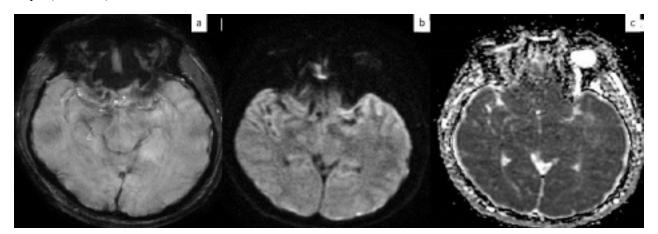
Axial (a) SWI image is normal. Axial DWI (b) and ADC (c) images, diffusion restriction was not found in the pseudo-SAH areas.
